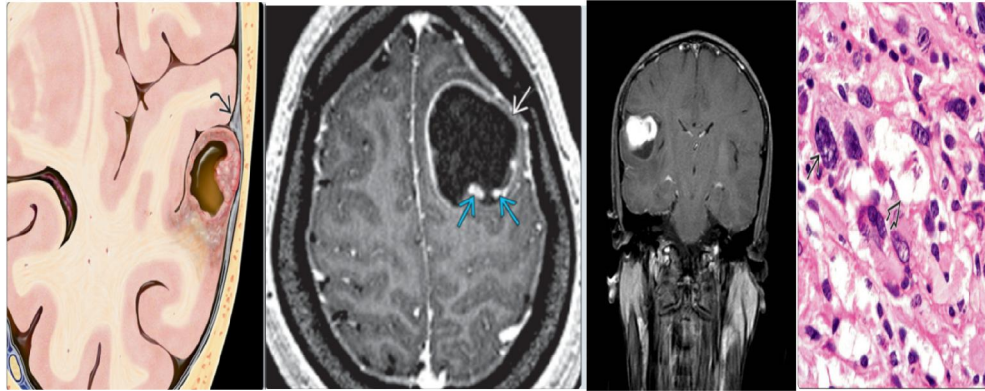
Coronal graphic shows a cystic and solid cortical mass with thickening of the adjacent meninges. Axial T1 C+ MR image shows a peripherally located frontal lobe mass, which abuts the dura with mild local mass effect. Solid, enhancing mural nodules are present. Conspicuous pleomorphism of the tumor with multinucleated giant cells and vacuolation characteristic for PXA, WHO grade II.
